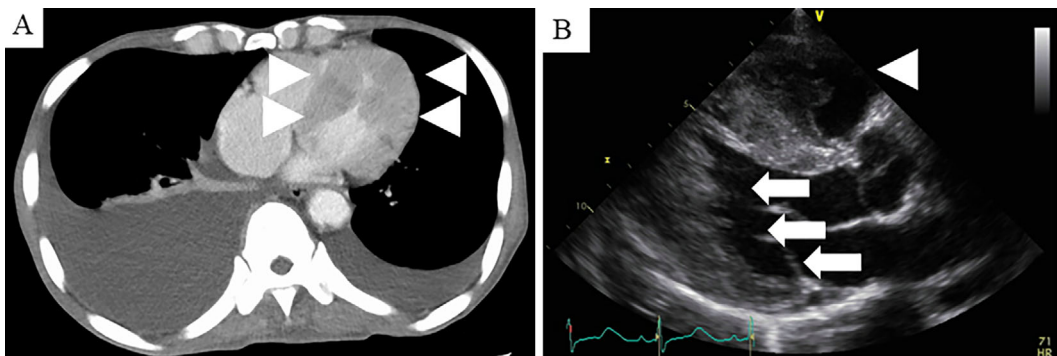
CT and TTE findings in the heart when complicated with ventricular arrhythmia. The progression of the tumor and wall thickening with the poor enhancement in the ventricular septum and wall are observed on CT (A; arrowheads), and the progression of the protruding mass in the ventricular septum (B; arrowhead) and exacerbation of diffuse thickening of the ventricular wall were detected with TTE (B; arrows).
